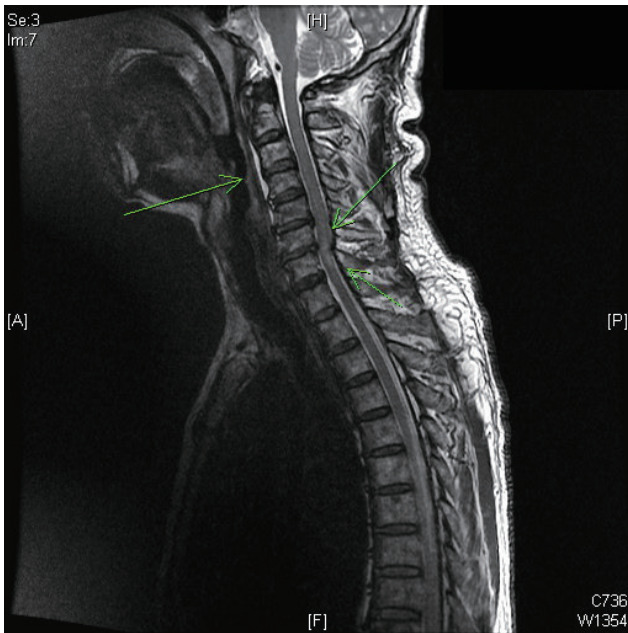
Initial MRI scan showed bone marrow edema in C6 and C7 vertebral bodies. MRI: magnetic resonance imaging.
